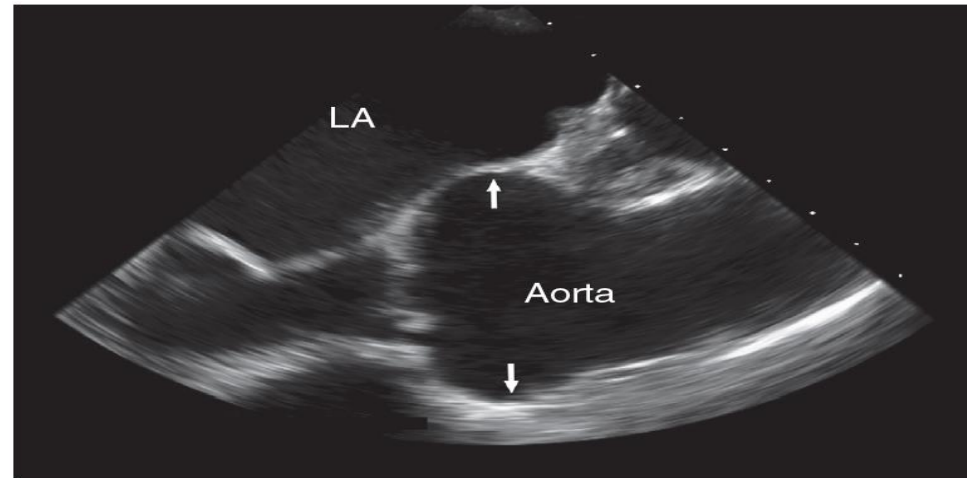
Transesophageal echocardiogram demonstrating an aortic root aneurysm of 53 mm (arrows) in an individual with Marfan syndrome. LA, Left atrium
